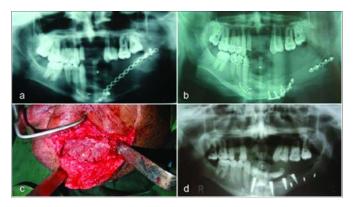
(a) Preoperative radiograph showing fractured miniplate across the continuity defect (b) Postoperaitve radiograph showing rib graft fixed with miniplates (c) Perioperative image of onlay iliac crest bone graft fixed with bicortical screws (d) Radiograph after implant placement for implant supported prosthesis.
